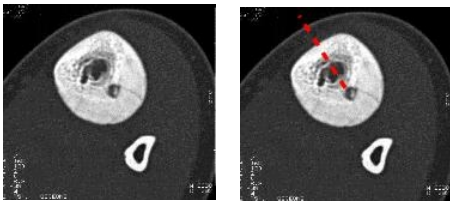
CT pathway for bone puncture
